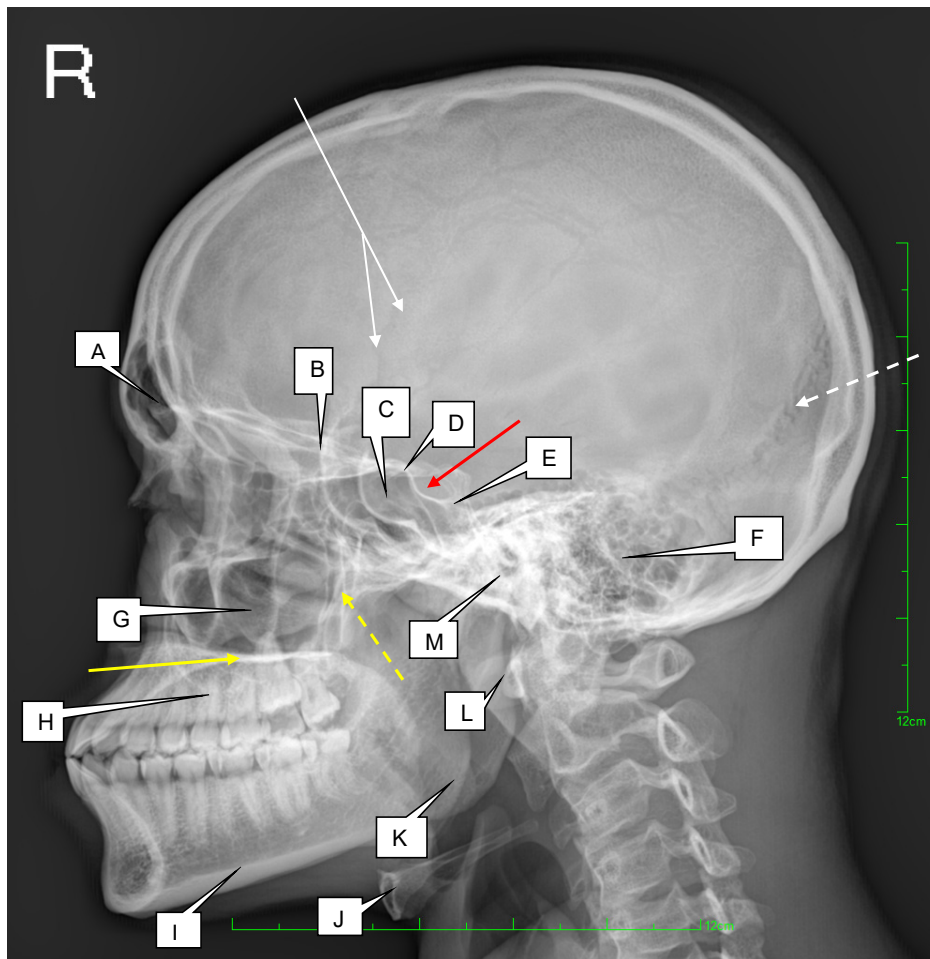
Lateral view radiograph of the skull of a young adult.
